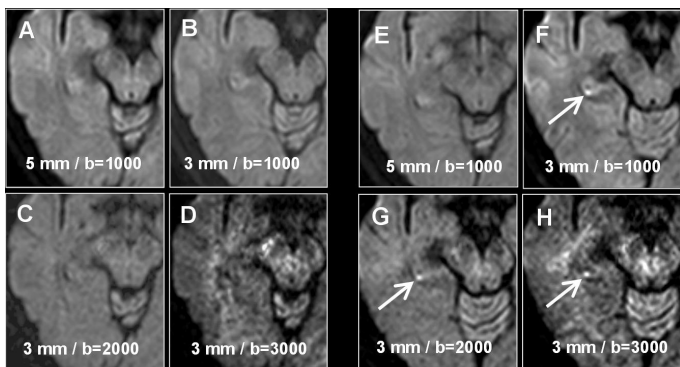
A 50-year-old lady presented transient global amnesia (TGA) for seven hours. The initial axial diffusion weighted imaging (DWI) of four different sequences, which were taken 4 hours after TGA attack, showed no abnormal lesion in the hippocampus (A-D). Follow-up DWI, 72 hours after symptom onset in the same patient, showed a small punctate (less than 2 mm) lesion of increased signal intensity in the right hippocampus
